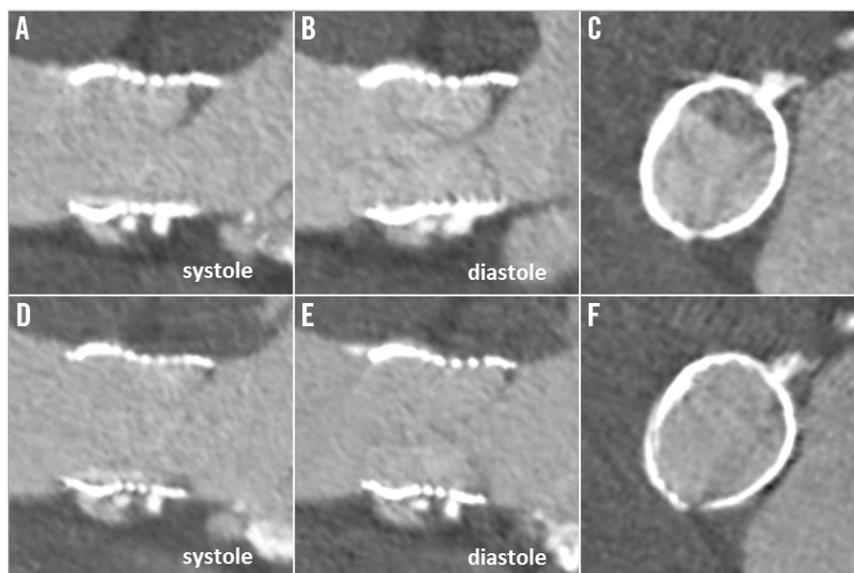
4D computed tomography angiography. 4D CTA on day 4 (A-C); 4D CTA on day 74 (D-F).
